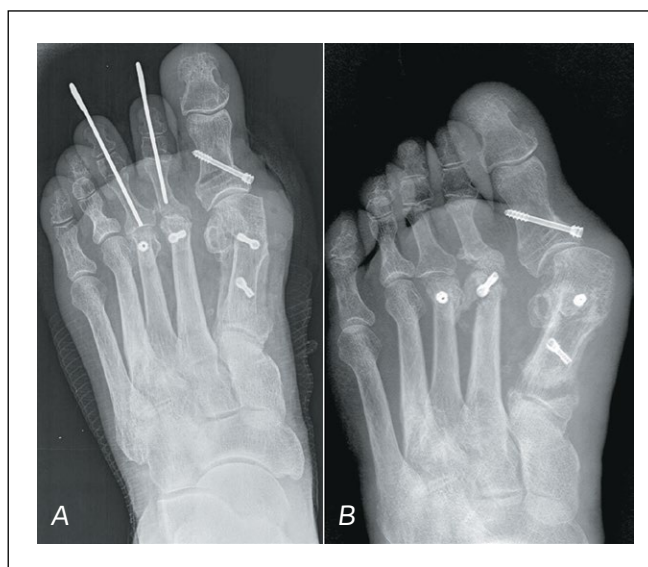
A – X-ray immediately after JPS (Scarf, Akin, Weil osteotomy); B – X-ray 6 months after JPS (aseptic necrosis of the head of the 2nd MB, instability of the Herbert screw, recurrence of the hallux valgus deformity of the 1st finger).
